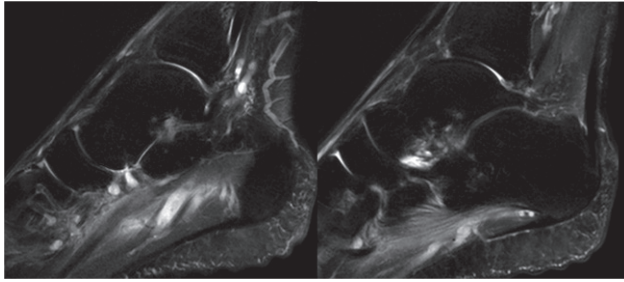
Sagittal fat suppressed T2-w MR images.
